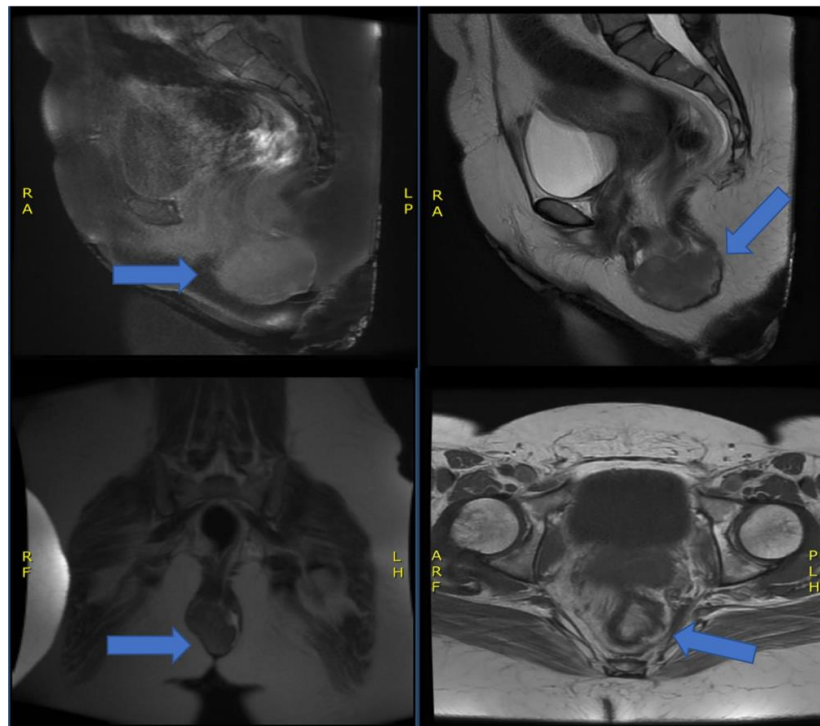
T2-weighted MRI of the pelvis showing heterogenous hyperintense perianal mass. Arrows point to the tumor.
